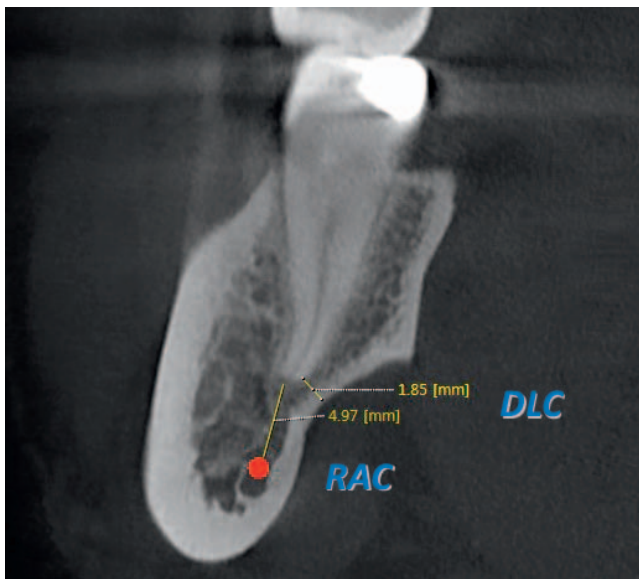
Measurement of distance to the outer lingual cortex and root-to-alveolar canal in first mandibular molar. Cross-sectional cone beam computed tomography reconstruction.
